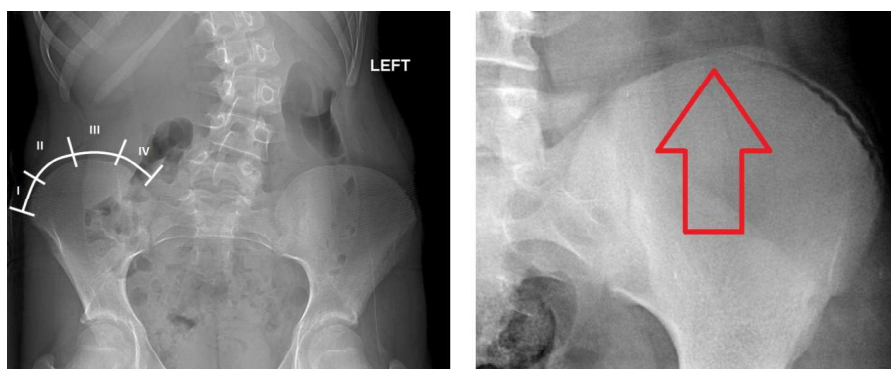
The Risser classification grades skeletal maturity based on the degree of ossification of the iliac crest apophyses. It begins with Risser Stage 0, where there is no ossification center at the level of iliac crest apophysis, and ends with stage 5, where there is complete ossification. Stages 1, 2, 3 and 4 are defined as 0 to 25% ossification, 25 to 50% ossification, 50 to 75% ossification, and 75% but less than 100% ossification, respectively. A Risser Stage 0 is shown in the x-ray at left, with a line indicating where the Stages 1 to 4 are defined. At right, a pelvic x-ray shows a Risser Stage 3 apophysis (Case courtesy of Dr Bruno Di Muzio, Radiopaedia.org, rID: 38297)
